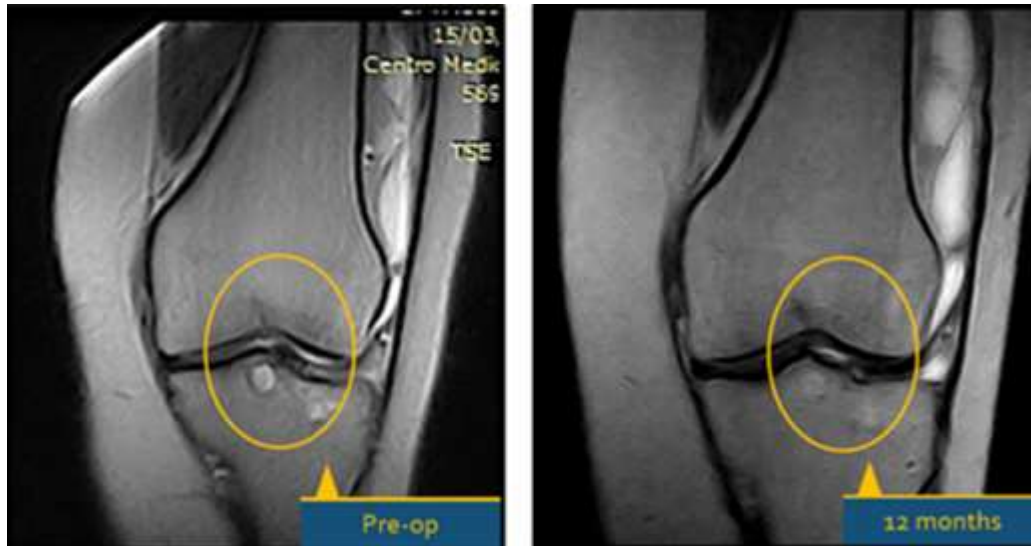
Osteo-Core-Plasty. M.R.I. of a tibial cyst treated with OCP, at 12 months follow-up. Images in correspondence with X-Rays in figure 11.
